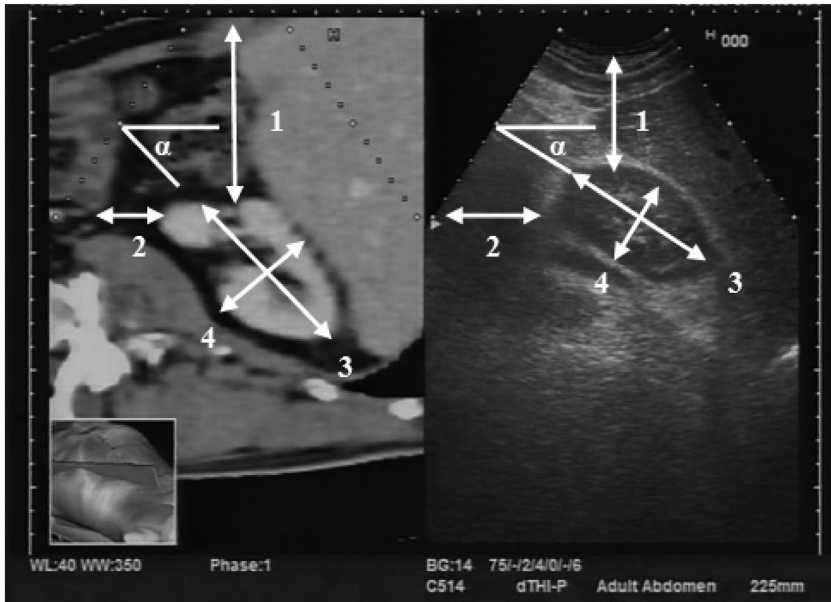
CT-navigated US: The actual US slice (right) is correlated with the respective CT image by electromagnetic tracking (see [Section 5.4: Diagnostic Ultrasound](#)). *Courtesy: PD Dr. M. Kranzfelder, Klinikum rechts der Isar.*
